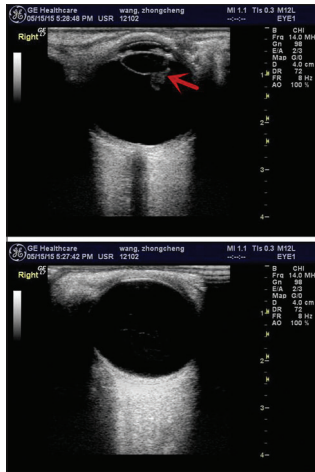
Color Doppler ultrasound of the injured eye demonstrated the posterior capsule rupture and the opacified cortex overflowed from the penetration passage (red arrow)
